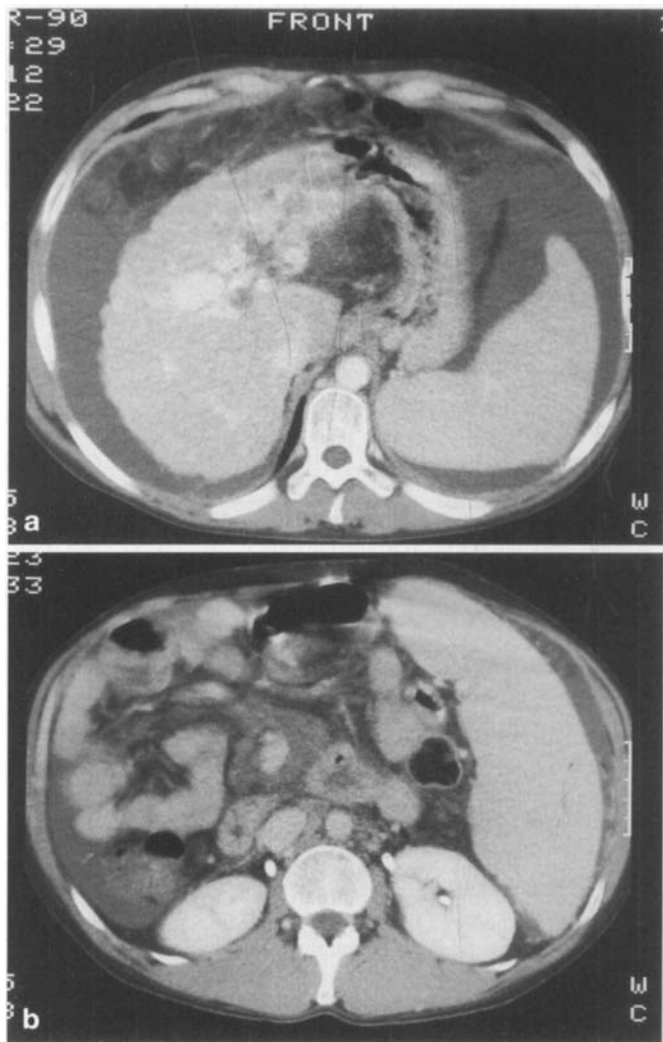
Abdominal CT scan showing extensive perivenous fat inflammatory changes reaching the infrapancreatic level. At transplantation, dissection of the phlebitic splanchnic veins, including the superior mesenteric vein, was responsible for uncontrollable bleeding
